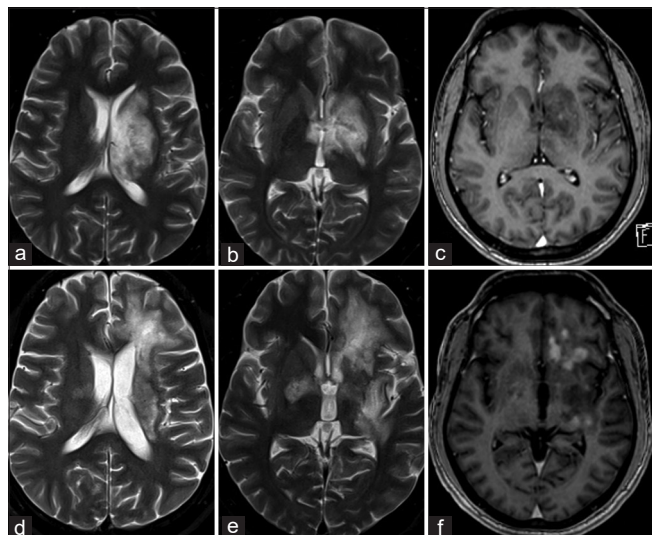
A 40-year-old male with lymphomatosis cerebri. Baseline axial T2W MRI (a and b) shows a predominantly T2W hyperintense lesion with interspersed intermediate signal areas, in the left periventricular white matter and basal ganglia. A small focus of micronodular contrast enhancement is seen within (c). Follow-up MRI brain (d-f) after 4 months of steroid therapy shows an increase in the extent of the lesion in bilateral cerebral parenchyma. New areas of macronodular contrast enhancement also suggest disease progression (f).
